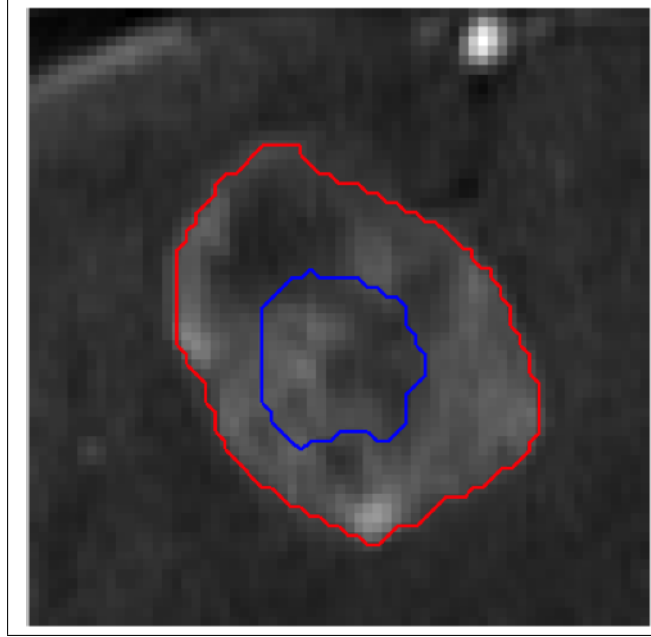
Red: Contour of the tumor in reference scan. Blue: Contour of the tumor in follow-up scan, overlaid on the reference MRI.
